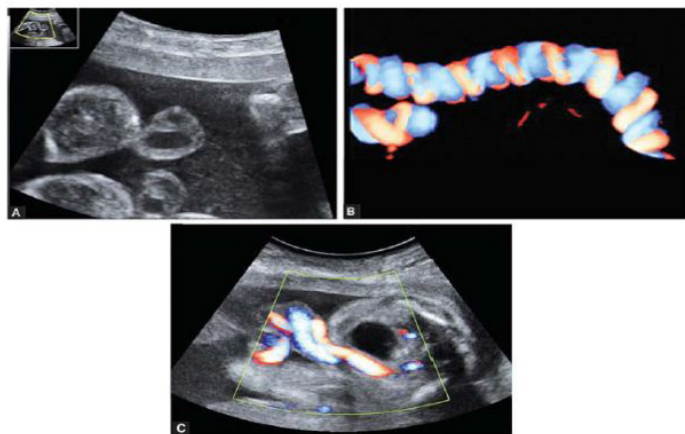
Shows three Trans abdominal USG images (A-C) depicting, A- transverse section of the triple vessel cord, B- color Doppler of the cord in longitudinal section & C- the insertion of the cord into the abdominal wall.
